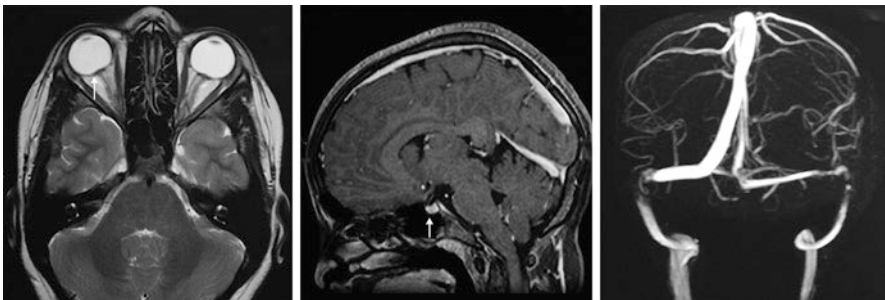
Neuroimaging in IIH. The first panel shows a T2-weighted axial MRI scan showing posterior globe flattening (white arrow) with protrusion of the optic papilla into the globe. The middle panel shows a T2-weighted sagittal MRI scan showing a partially empty sella (white arrow). The third panel shows an MR Venogram demonstrating narrowing of both transverse sinuses
